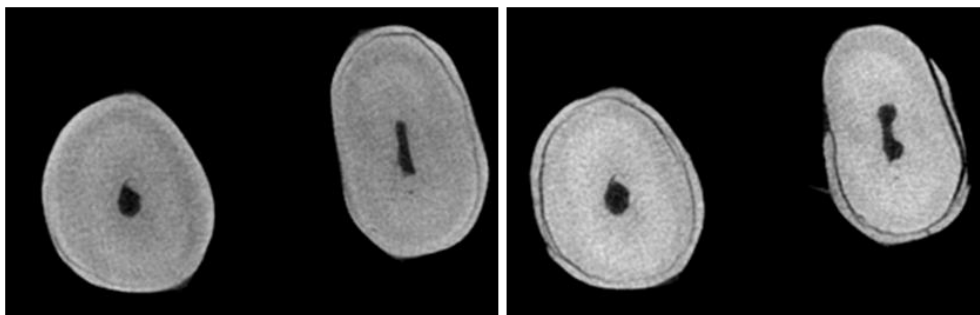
The μ CT cross-section images of the tooth before and after instrumentation (left and right, respectively)
